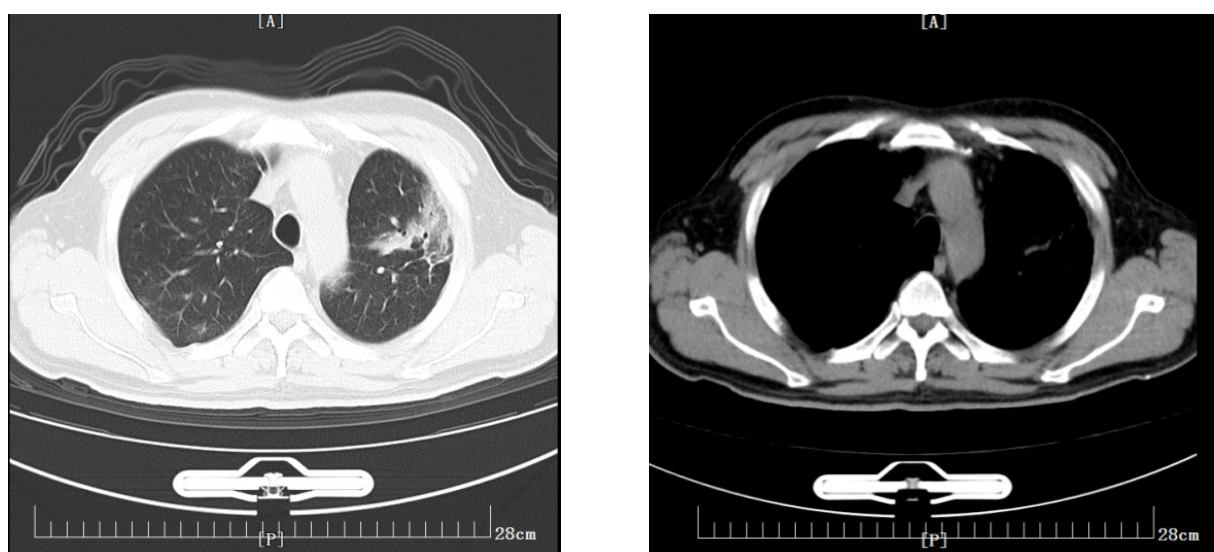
Chest CT upon admission. (Left) Lung window: consolidation and ground-glass opacities in the upper lobe of the left lung; (Right) Mediastinal window: consolidation visible
